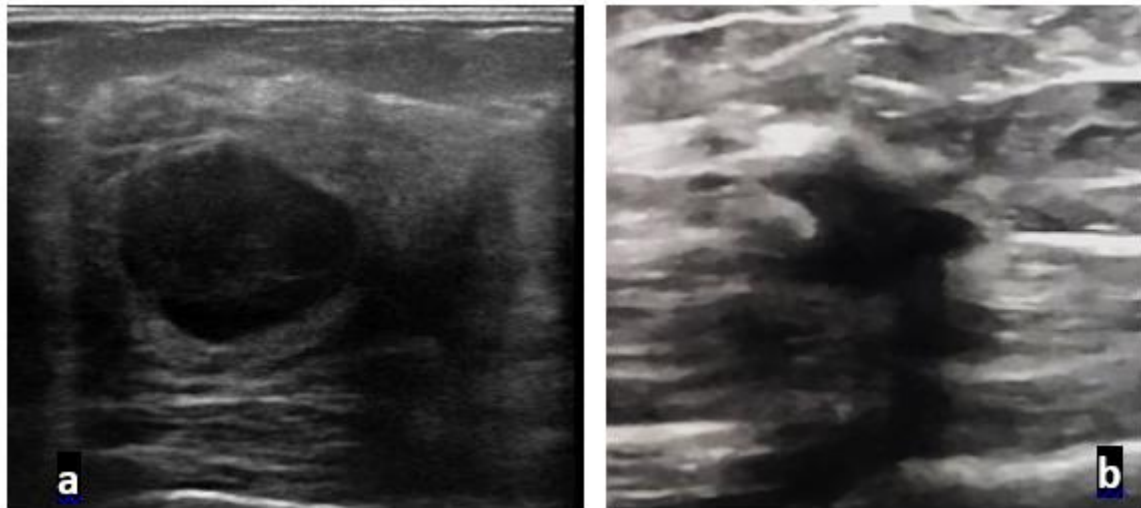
Shapes of masses on ultrasound. a: Oval-shaped mass, b: Round-shaped mass, c: Irregular-shaped mass
